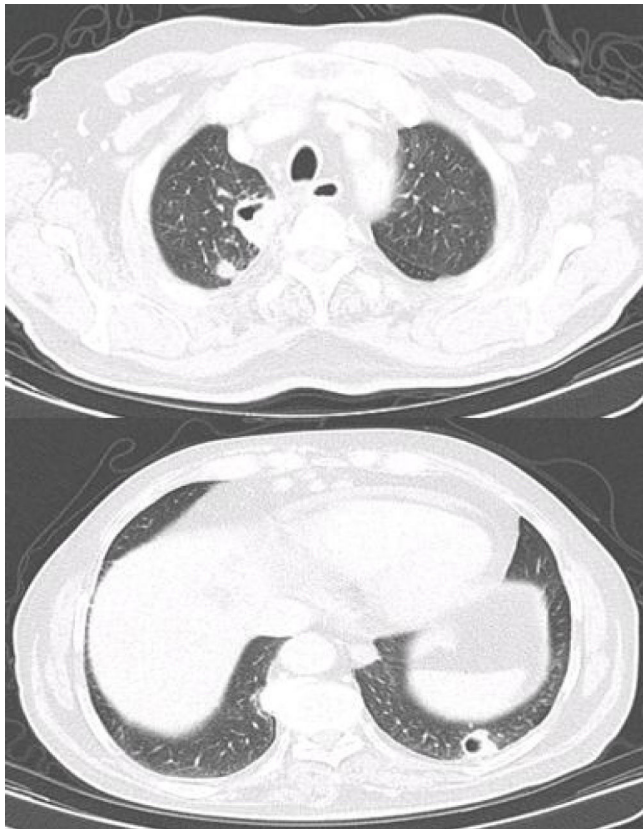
Thoracic CT scan – axial plan – multiple peripheral nodules of both lungs, the bigger ones, cavitated.
